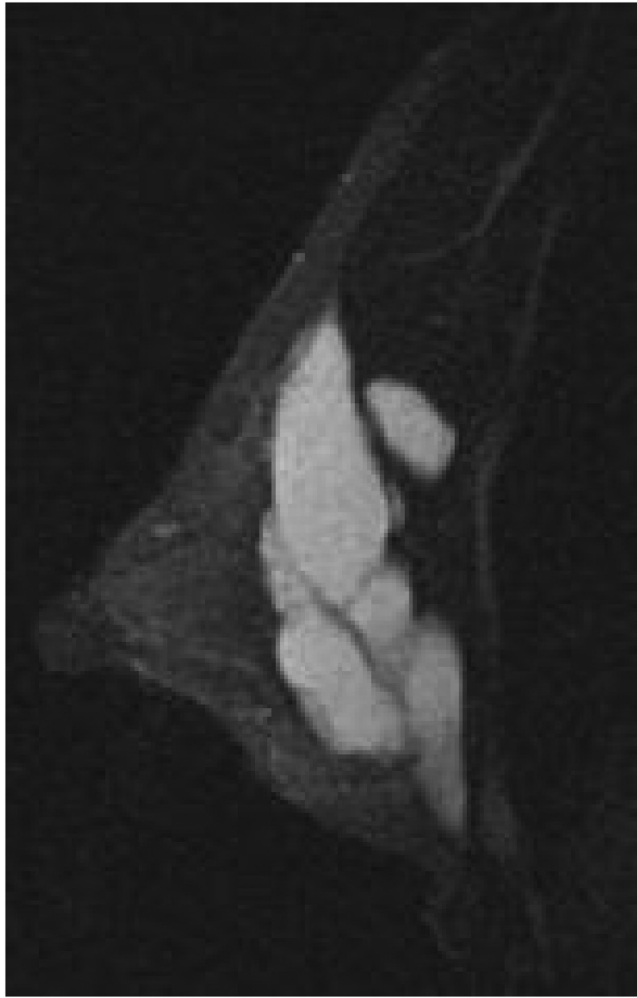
Appearance of Macrolane as multiple deposits following re-treatment (6 months post-treatment) on MRI (sagittal STIR).
